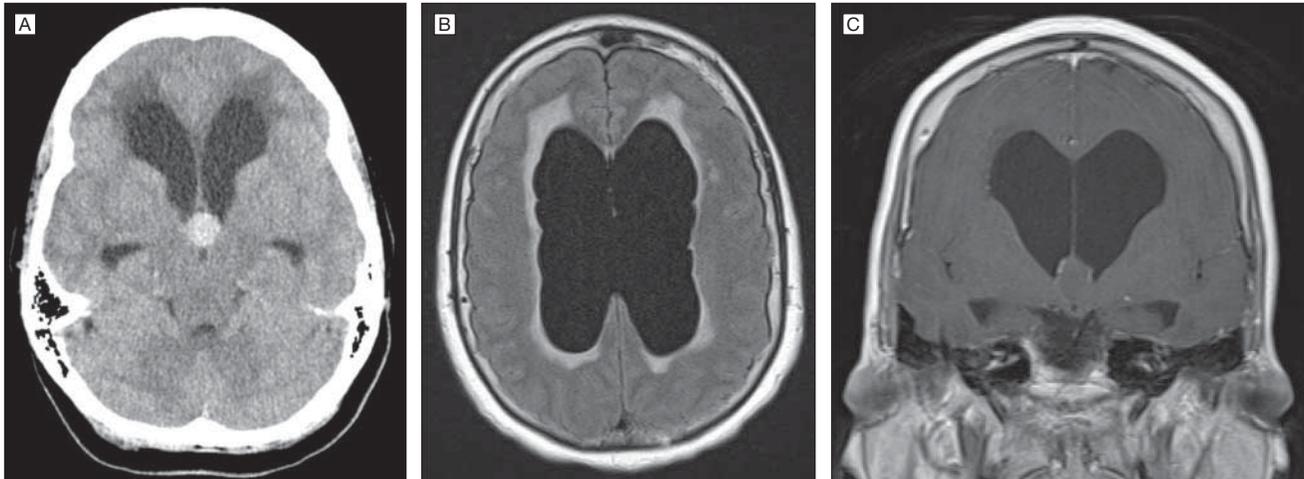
A, Axial noncontrast head computed tomography (CT) scan demonstrating significant hydrocephalus with periventricular hypodensity consistent with transependymal flow and a well-circumscribed hyperdense lesion in the third ventricle. B, Axial fluid-attenuated inversion recovery magnetic resonance imaging (FLAIR MRI) demonstrating enlarged lateral ventricles with periventricular hyperintensity indicative of transependymal flow. C, Coronal T1-weighted postcontrast MRI demonstrating enlarged lateral ventricles and a lesion in the third ventricle obstructing the foramen of Monro bilaterally.
